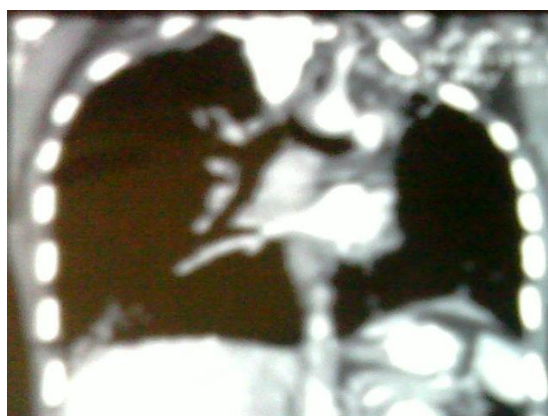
(a): Coronal CT of chest (lung window) showing well-defined cystic lesion in the right lower lobe
